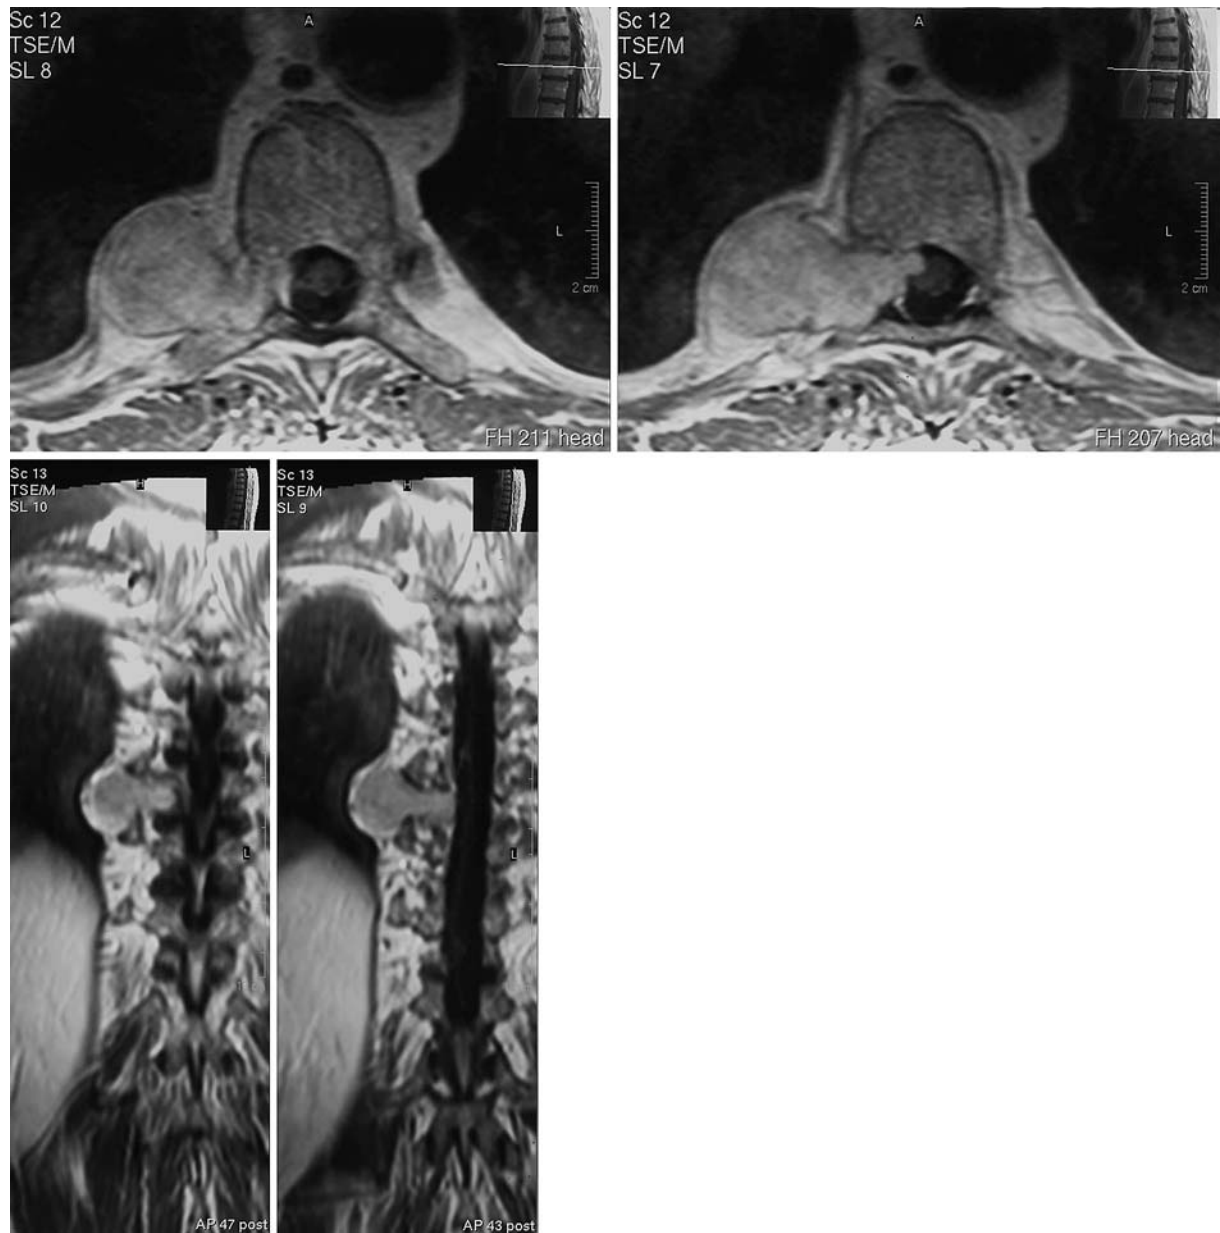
MR images demonstrating a right dumb-bell intra-extradural mass at T9–T10 level extending into the intrathoracic right space for about 2.5 cm. Coronal and axial T1-weighted images with Gd-DTPA enhancement
